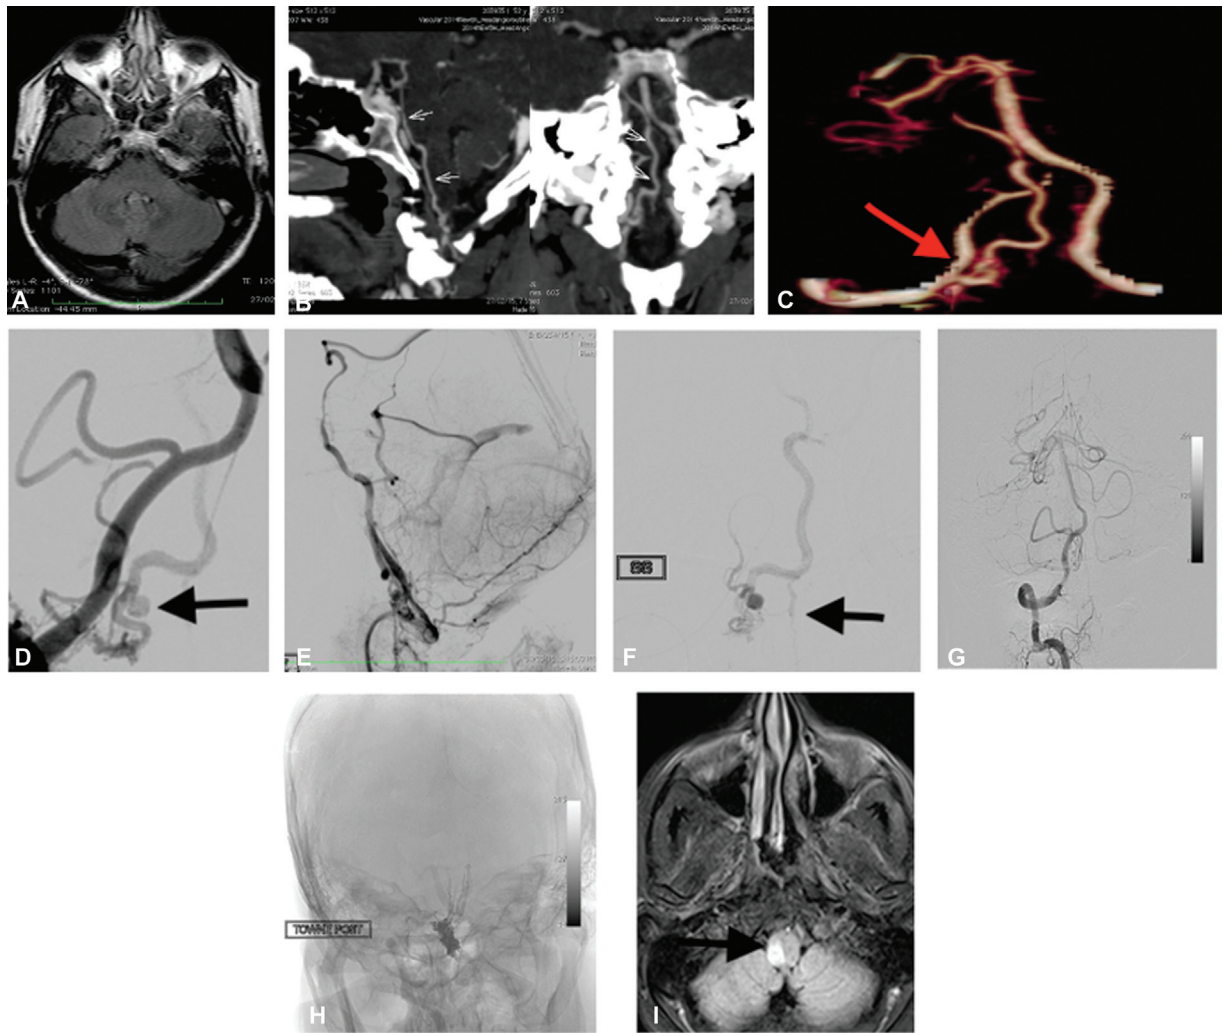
(A) Fluid-attenuated inversion recovery magnetic resonance imaging sequence demonstrating bright appearing lesion in the 4th ventricle. (B) Computed tomography angiography showing abnormal early enhancing vein along the course of the basilar artery (*arrows*). (C) Reformatted CTA showing fistula very close to the V3–V4 segment junction (*arrow*). DSA of right vertebral artery AP (D) and Lat (E) showing fistula principally fed by lateral medullary branch arising from V4 segment with aneurysm of draining vein (*arrow*). Super selective run (F) showing caudal perimedullary venous drainage along with the cranial drainage (*arrow*). (G) Post procedure, vertebral artery angiogram showing complete obliteration of the fistula. (H) Subtracted image showing Onyx cast into the fistula, aneurysm, and foot of the draining vein. (I) Diffusion weighted image showing acute infarct in the lateral medulla.
